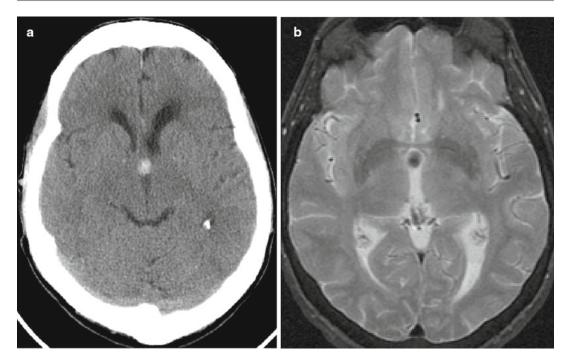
Colloid cyst. Unenhanced CT (a) shows a hyperdense lesion anterior to the third ventricle that is seen as a low-signal lesion on T2-weighted MRI (b)
